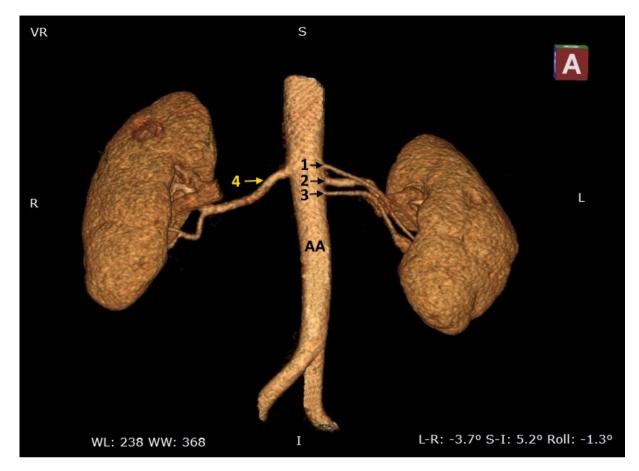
The CT scan (image with 3D reconstruction) presents the abdominal aorta (AA) and departing left renal arteries (black arrow): 1 - first additional, 2 - main, 3 - second additional and 4 - renal artery right (yellow arrow).
